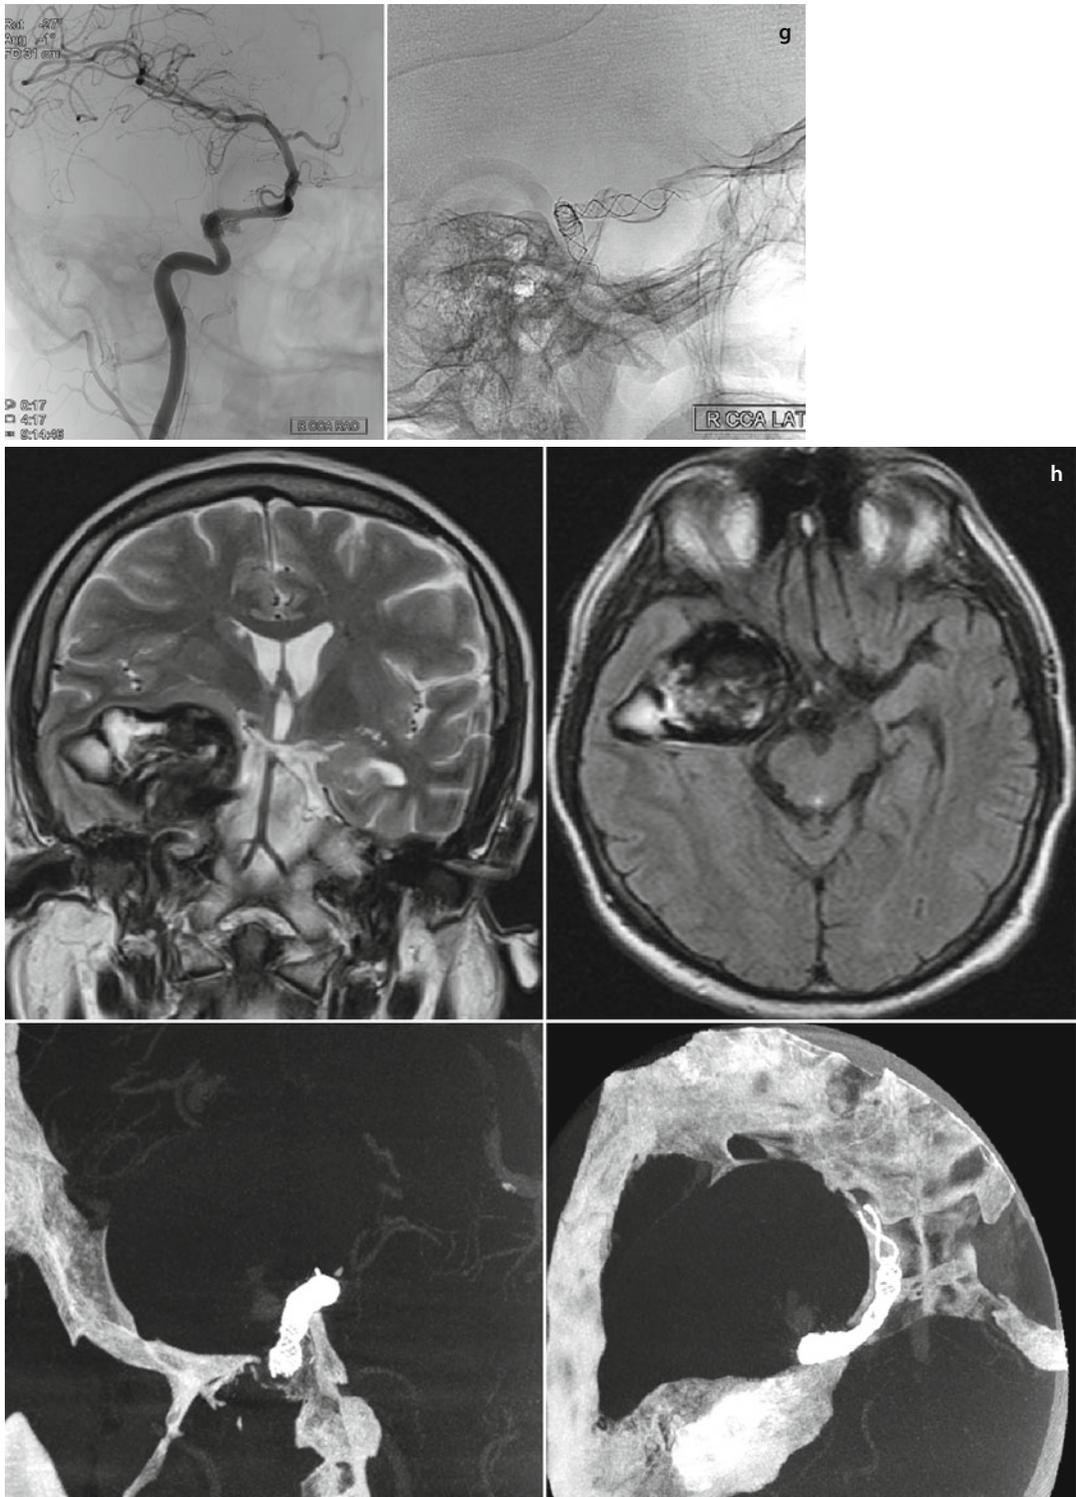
(continued) (d) The patient has progressive improvement in his ophthalmoplegia. Control angiogram at 1 year reveals persistent residual filling in the vicinity of aneurysmal neck. (e) The patient presented after 2½ years of second treatment with headaches. T2W and postcontrast MRI images reveal onion skin appearance of thrombosed aneurysm with substantial increase in the aneurysmal size, peri-aneurysmal vasogenic edema, and mass effect on temporal lobe. (f) Cerebral DSA and IA VASO CT® at 2½ years of second treatment show persistent mild filling around aneurysmal neck and increased aneurysmal size measuring 52 × 50 mm. There was good cross flow across the anterior communicating artery from left cerebral circulation with no significant delay.
